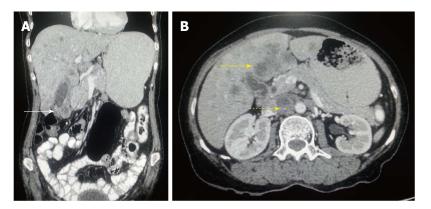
Carcinoma gallbladder: Nodal and hepatic metastasis. A: Coronal contrast-enhanced computed tomography (CECT) abdominal section shows relatively defined heterogenous mass involving fundus of gall bladder (arrow) with loss of fat plane with adjacent hepatic segment; B: Axial CECT abdominal section shows multiple hepatic metastasis (arrow) along with interaortocaval lymph nodal metastasis (dashed arrow).
